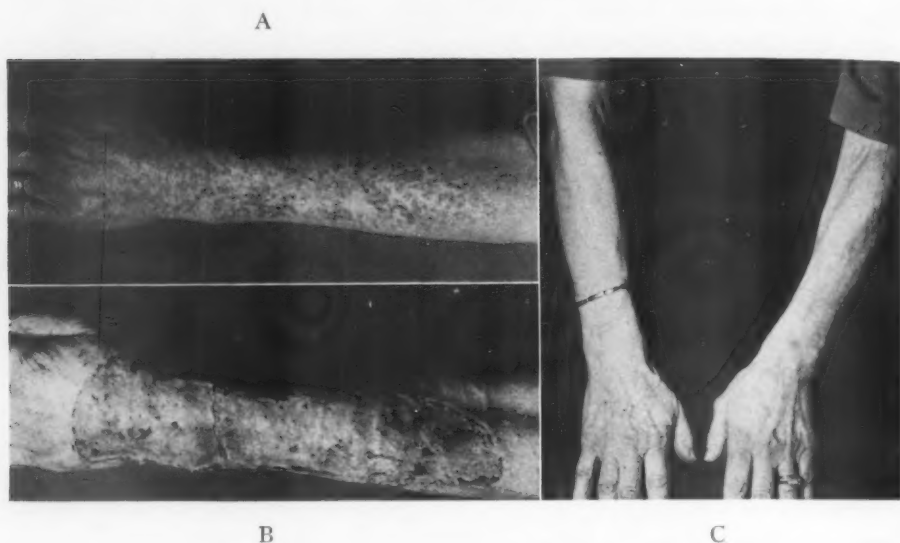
(A) Extensive roentgen ray burn following commercial epilation treatment. (B) Immediate appearance following resection and repair with split grafts. One operation. (C) Result 17 years later, showing normal appearance and persistence of function of the grafted skin.
